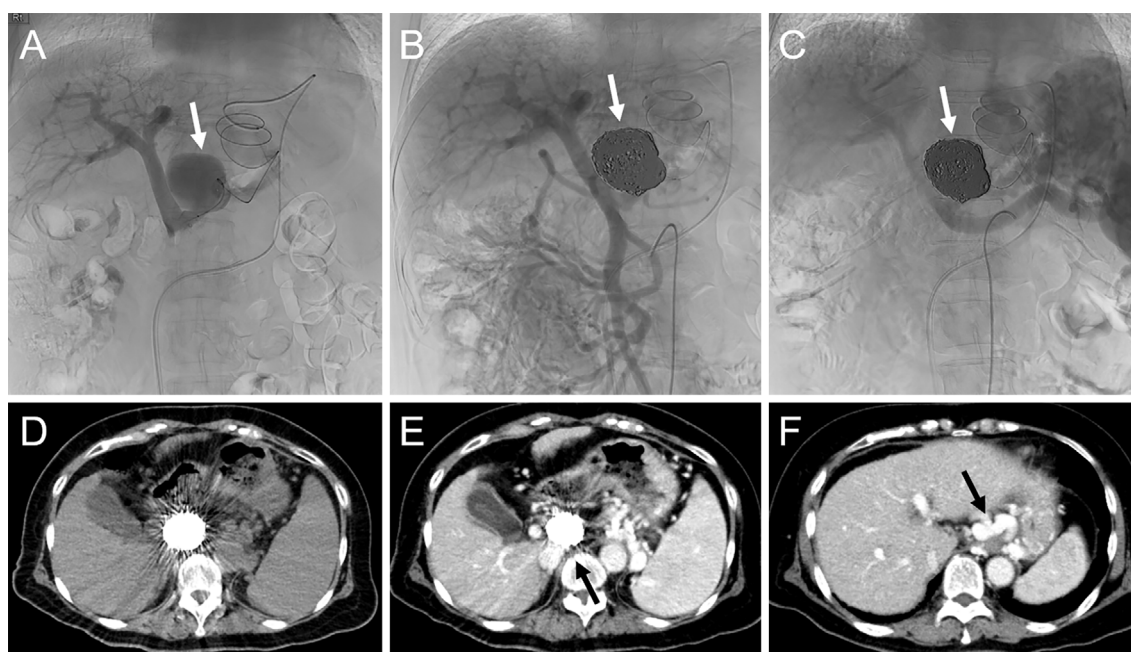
Through a gastorenal shunt, we performed coil embolization of the left gastric vein aneurysm (arrow). After treatment of the aneurysm, we checked the blood flow of the portal venous system, including the left gastric vein. A) Portography before treatment. B) Arterioportography of the superior mesenteric artery after treatment. C) Arterioportography of the celiac artery after treatment. D) Non-contrast-enhanced computed tomography (CT). E) Dynamic contrast-enhanced CT eight days after treatment, showing neither blood flow in the aneurysm (arrow) nor portal vein thrombosis. F) Remaining blood flow of the gastrorenal shunt (arrow).
